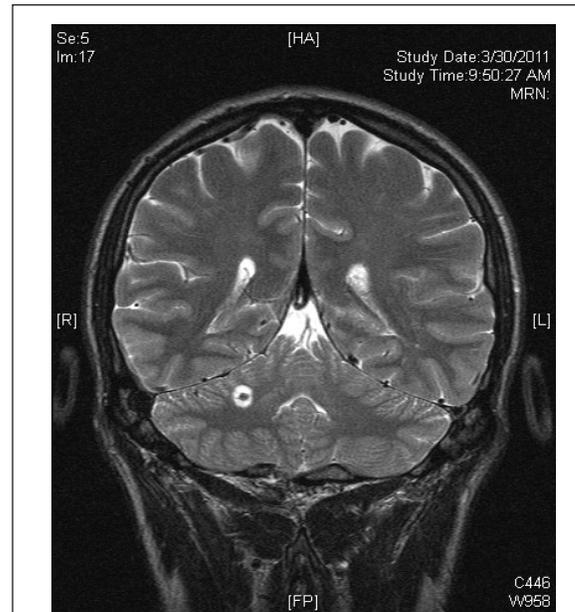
MRI scanning and imaging of initial cerebellar lesions
